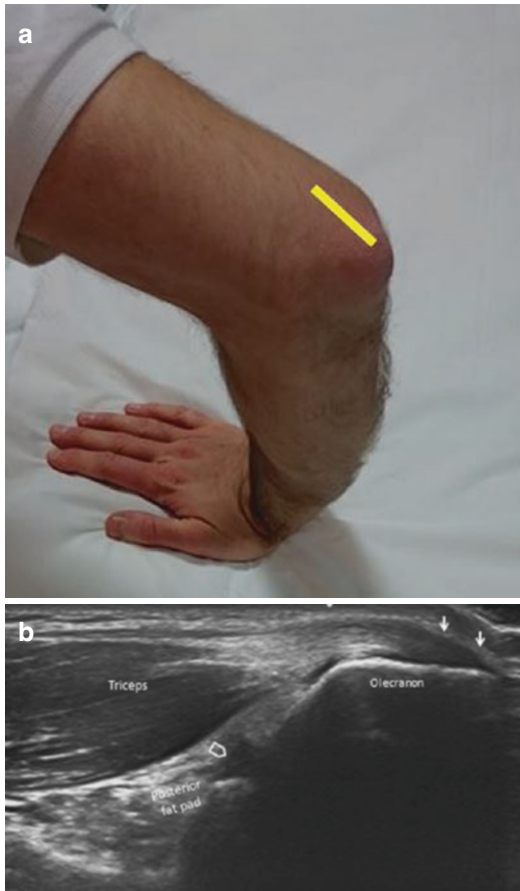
Triceps tendon. Transducer placement (a). The distal triceps tendon (b) appears as a fibrillary echoic structure. Pre-insertional fibers appear hypoechoic owing to the anisotropy artifact (arrows). Ultrasound examination of the triceps tendon can be performed on transverse and longitudinal planes moving the transducer from myotendinous junction to the olecranon. Deep in the triceps, the olecranon fossa, the posterior recess (void arrow), and the posterior elbow fat pad may be evaluated
